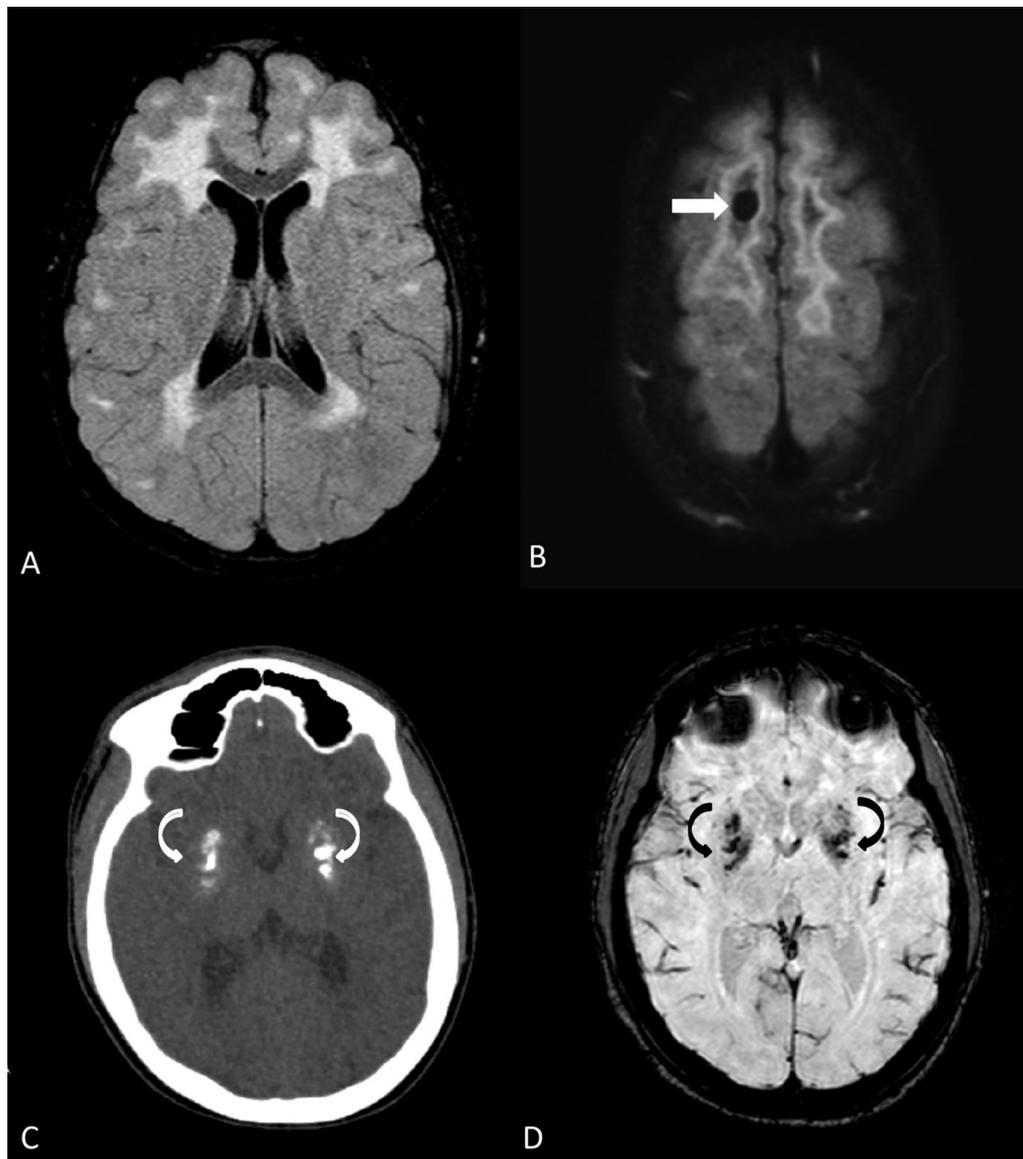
Axial FLAIR (fluid-attenuated inversion recovery) MRI sequence at age five years (A) shows bilateral symmetric areas of white matter hyperintensity. The white matter hyperintensity was more severe in the frontotemporal region with sparing of the internal and external capsules. Axial FLAIR image (B) at the level of the vertex showed a focal cystic change (arrow). Axial noncontrast computed tomography (C) at age 14 years shows bilateral symmetric globus pallidus calcification (curved arrows) corresponding to the reduced signal lesions (curved arrows) on the axial susceptibility sequence of the brain MRI (D).
